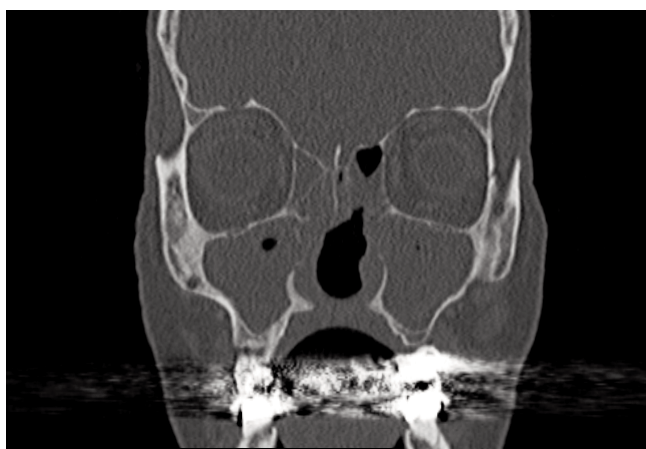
CT appearance: sinus opacification and marked medial bony erosion, with absence of a bony palate.
